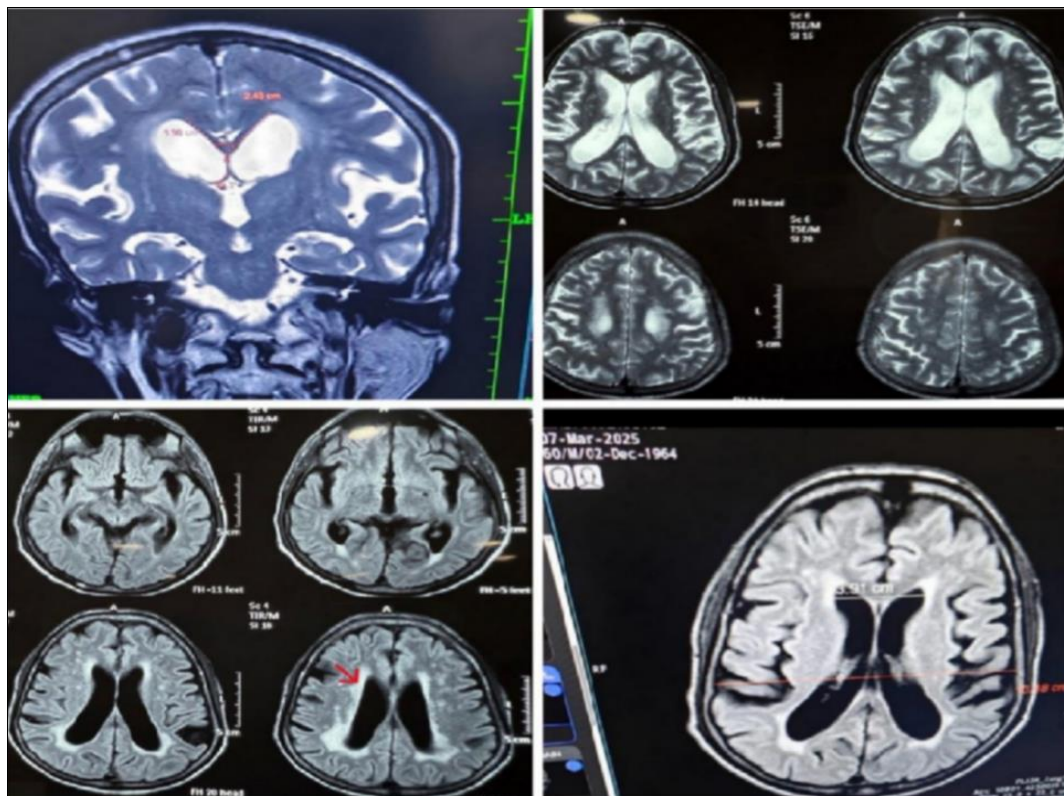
MRI brain top left coronal image showing dilated supratentorial ventricular system, dilated sylvian fissure with narrow upward bowing of callosal angle of 79 degrees (which is less than 90 degrees), top right showing dilated ventricles with superficial sulci, below left axial image showing interstitial edema around the lateral ventricles (in red arrow), below right axial image showing two lines depicting the Evans index which is the ratio of the maximum width of the frontal horns of lateral ventricles and maximal internal diameter of the skull that comes out to be 0.29 here, which denotes ventriculomegaly.
